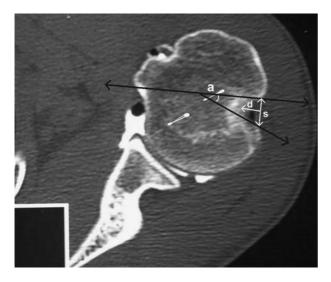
Preoperative double contrast CT arthrography of a 20-year-old patient.
